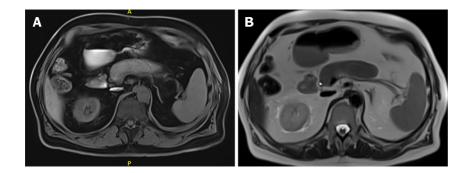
Radiological appearance of autoimmune pancreatitis-part 2. A: Unenhanced T1 weighted magnetic resonance imaging (MRI) images of autoimmune pancreatitis (AIP): Diffuse hypointense pancreas, with an even more hypointense fibrotic capsule-rim; B: Unenhanced T2 weighted MRI images of diffuse AIP: The affected parenchyma shows a moderately higher intensity signal, with a persistently low-intensity fibrotic rim.
